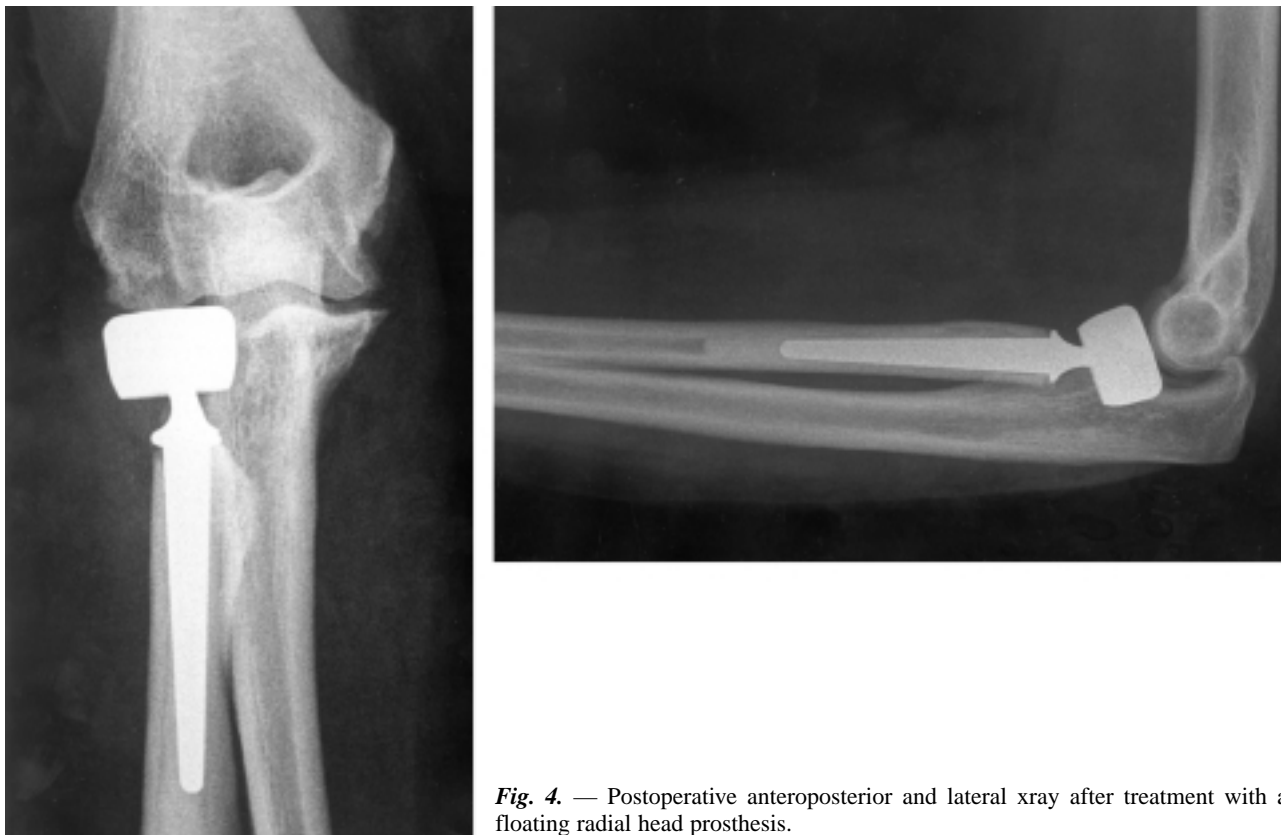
Postoperative anteroposterior and lateral xray after treatment with a floating radial head prosthesis.
